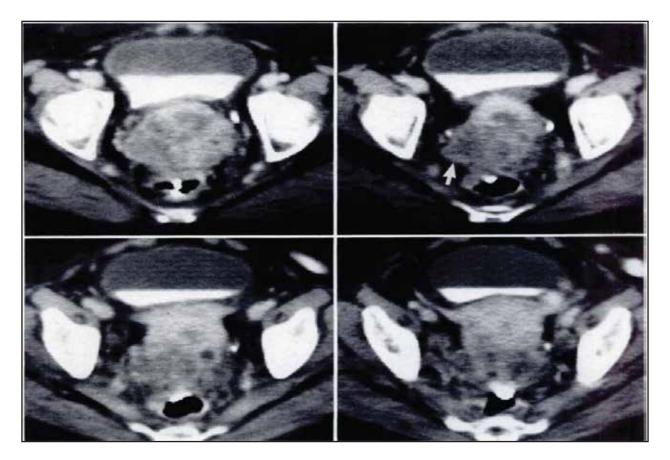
CT images of clinical stage IVA cervical carcinoma. Sequential CT scan images show a heterogeneous enhancing hypodense cervical mass with right parametrial soft tissue, left parametrial fat stranding, obliteration of periureteric and pre-rectal fat plan with rectal wall invasion.
